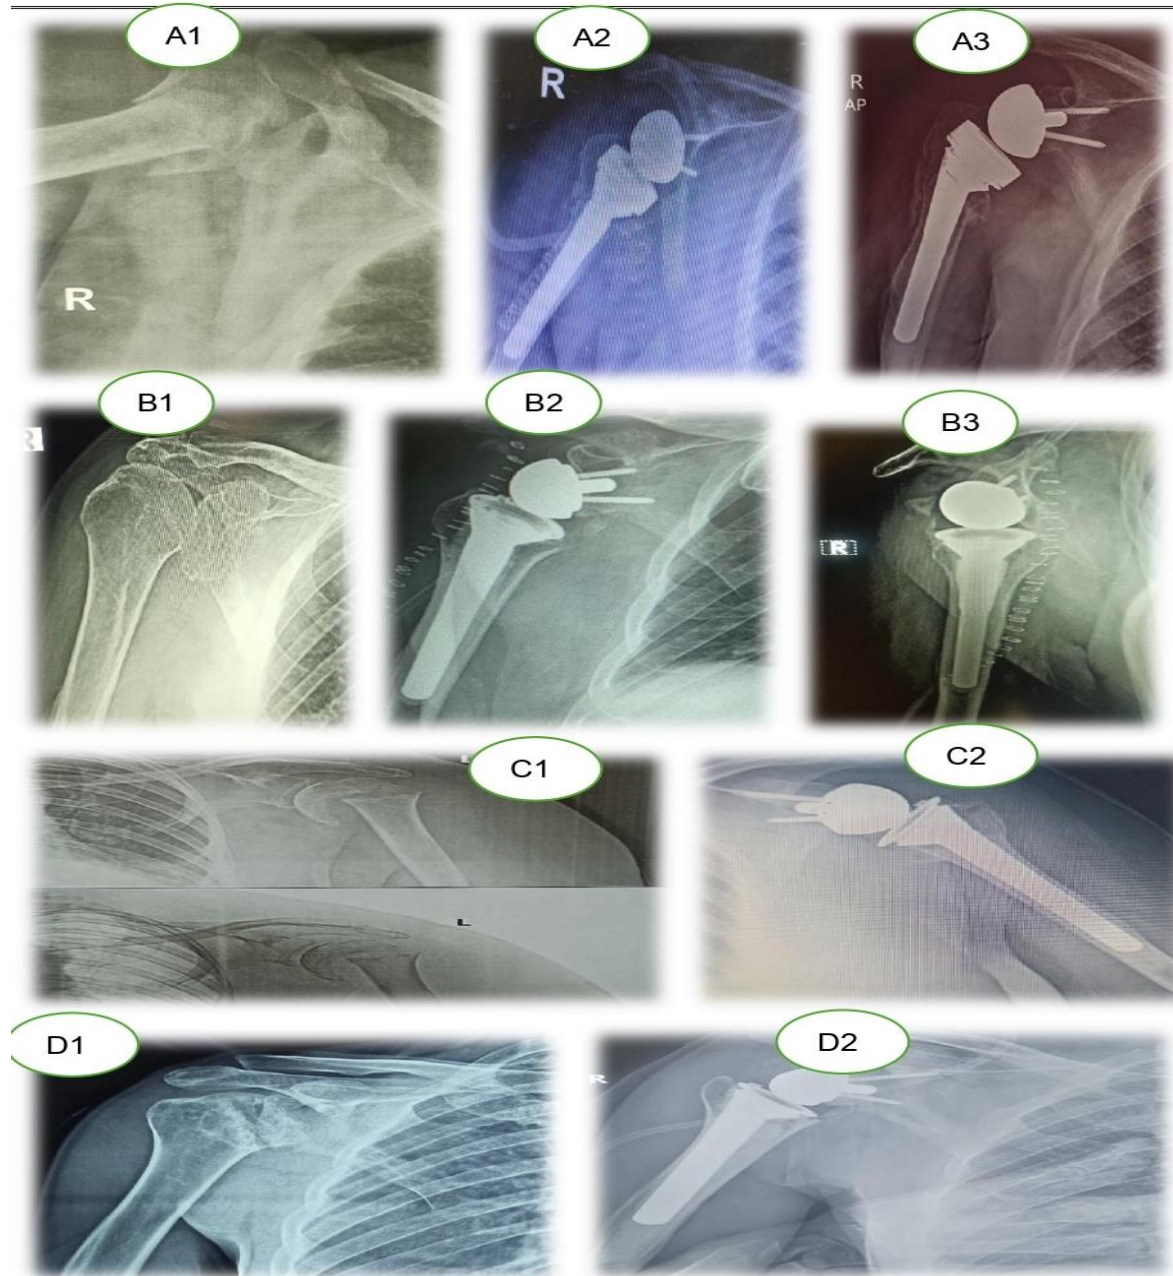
Pre-operative and post-operative x-ray for Reversed shoulder arthroplasty in different indications as show: [A1] PHF Pre-operative x-ray, [A2 and A3] PHF post-operative x-ray,[B1] CTA Pre-operative x-ray,[B2 and B3]CTA Pre-operative x-ray,[C1]fracture sequale Pre-operative x-ray,[C2] fracture sequale Post-operative x-ray,[D1] neglected posterior shoulder dislocation Pre-operative x-ray and ,[D2] neglected posterior shoulder dislocation Post-operative x-ray.
